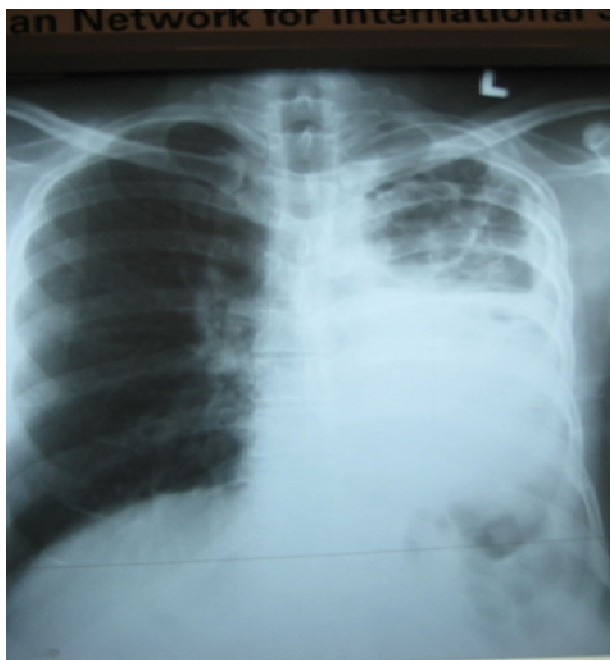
Chest radiograph of the patient showing pleural collection, pulmonary fibrosis and infiltrates on the left side.
